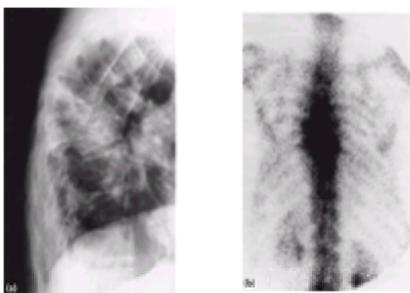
(a) Recurrent tuberculosis. This patient had previously been treated for tuberculosis but returned some years later complaining of recurrent back pain. From the radiographs it was impossible to determine whether there was any active infection. (b) The skeletal scintigram showed increased uptake at the site of the previous infection. This appearance, together with the symptoms, suggested that she had reactivated tuberculosis and required a further course of therapy.
